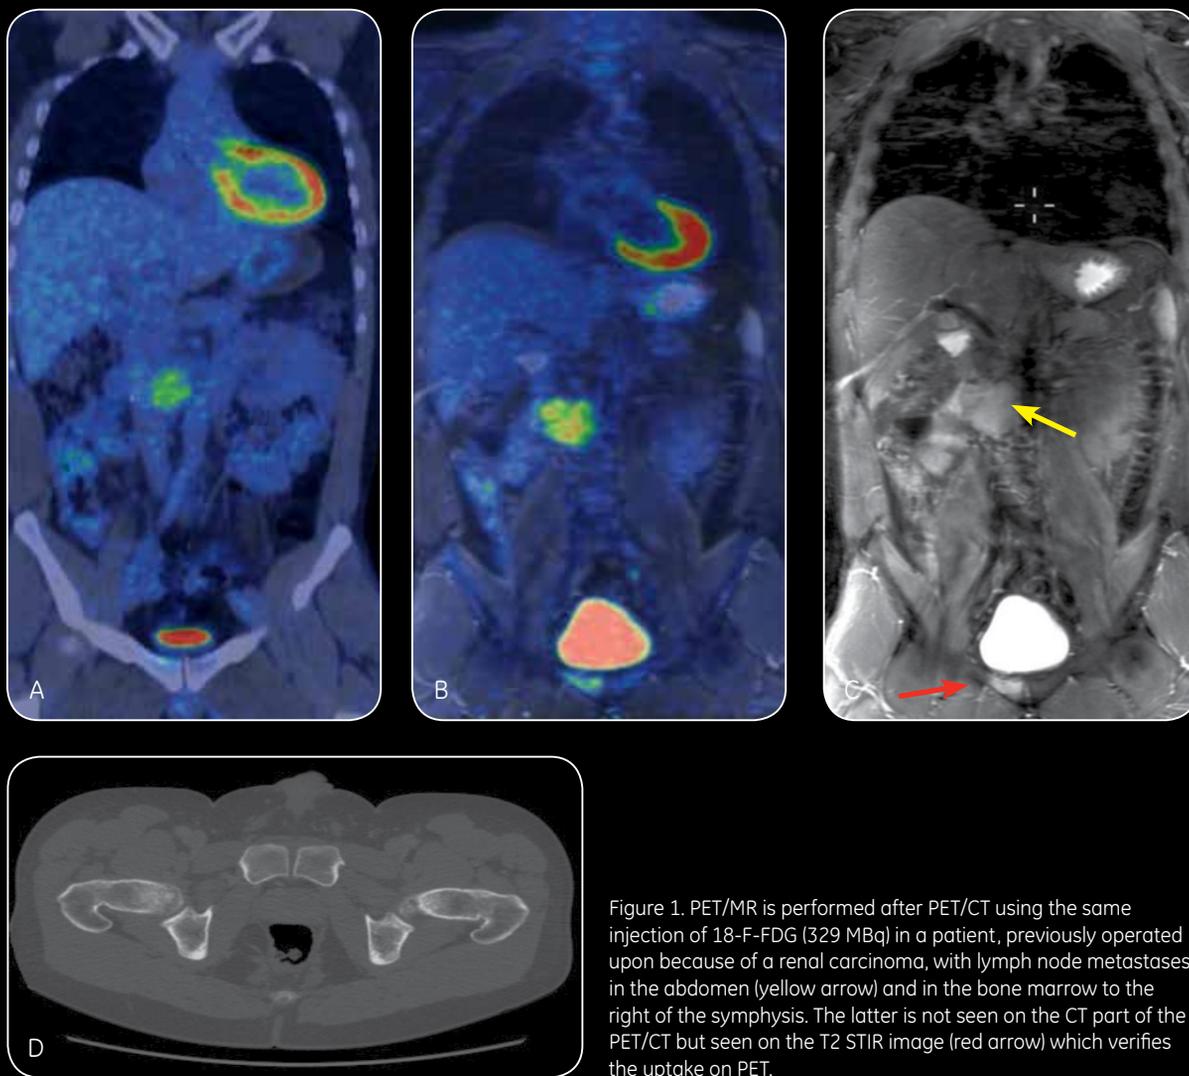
PET/MR is performed after PET/CT using the same injection of 18-F-FDG (329 MBq) in a patient, previously operated upon because of a renal carcinoma, with lymph node metastases in the abdomen (yellow arrow) and in the bone marrow to the right of the symphysis. The latter is not seen on the CT part of the PET/CT but seen on the T2 STIR image (red arrow) which verifies the uptake on PET.
